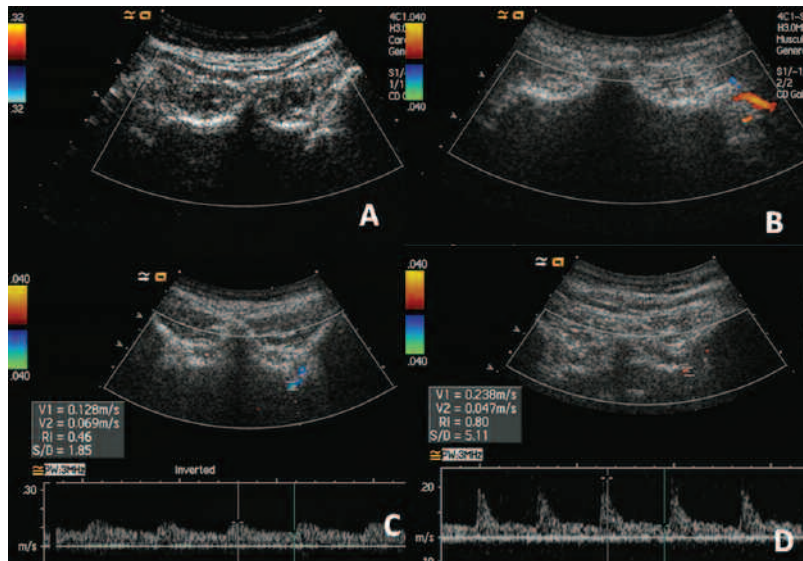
Color Doppler ultrasonography and spectral Doppler images of sacroiliac joints (SIJ) of patients with ankylosing spondylitis. A. No color Doppler signals in either SIJ. B. Color Doppler signals around the left SIJ. C. Color Doppler signals inside the left SIJ showing low resistance (0.47) on spectral Doppler analysis. D. Color Doppler signals inside the left SIJ showing high resistance (0.80) on spectral Doppler analysis.
